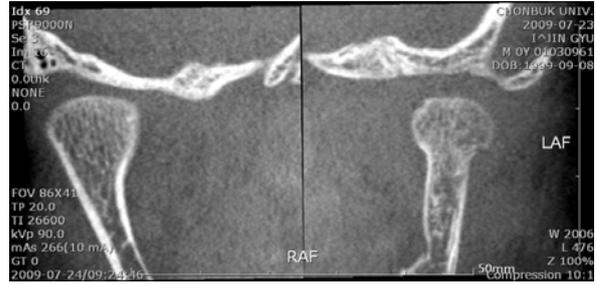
Coronal view of left mandibular condyle at 4 month after discharge by cone beam CT.
